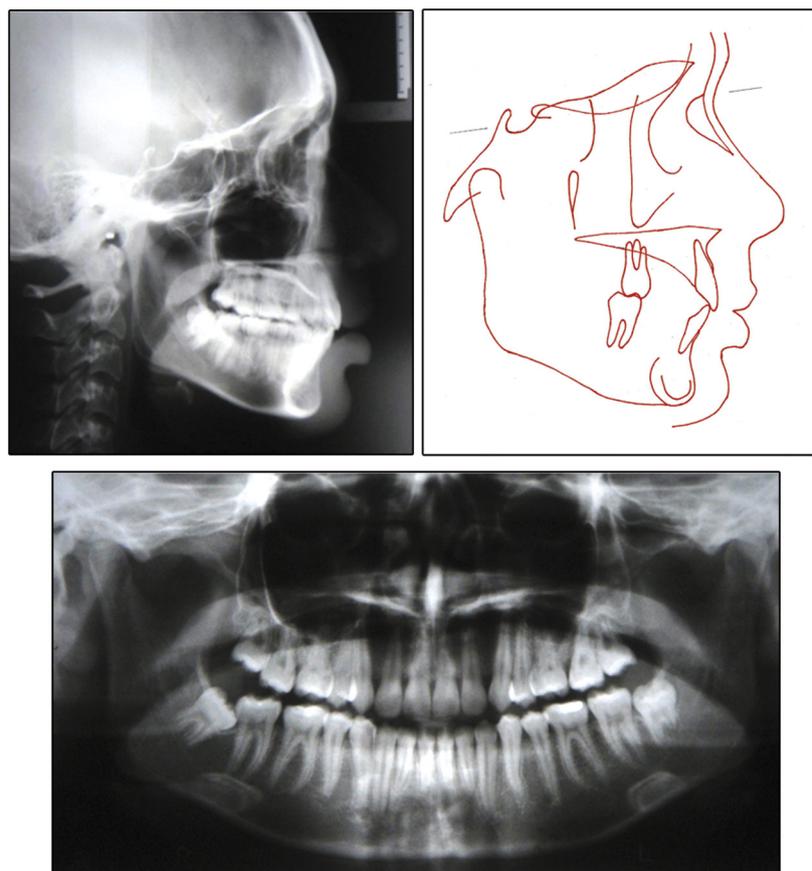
Posttreatment cephalometric radiograph, cephalometric tracing, and panoramic radiograph.
